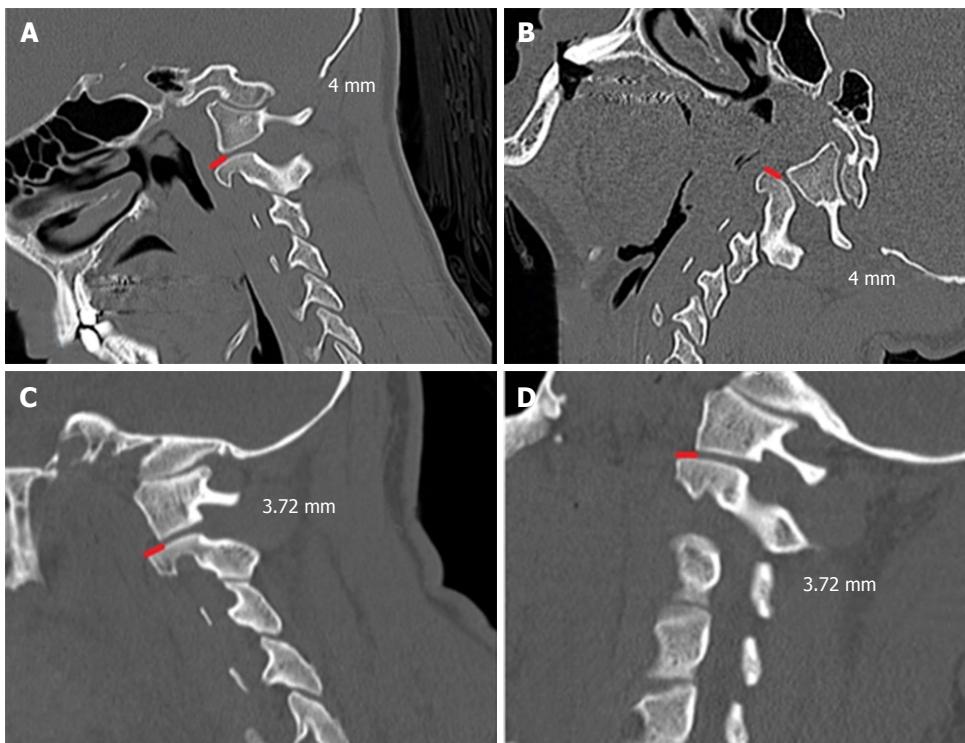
Dynamic sagittal computed tomography scan of 15-year-old boy, which had the diagnosis of a tonsillar herniation of 9.4 mm and basilar invagination. In both A and B positions, the facet dislocation of the C1 lateral mass posteriorly to the superior C2 joints was maintained (4 mm). We opted to perform only posterior fossa decompression without craniovertebral junction instrumentation, obtaining a good clinical improvement; C and D: Dynamic sagittal computed tomography scan imaging - a forty-six-year-old man, with tonsillar herniation of 7.44 mm. In both positions the facet dislocation of the C1 lateral mass over the C2 superior facet joint was 3.72 mm. We also performed only a posterior fossa decompression without fusion in this patient, with a good clinical outcome.
